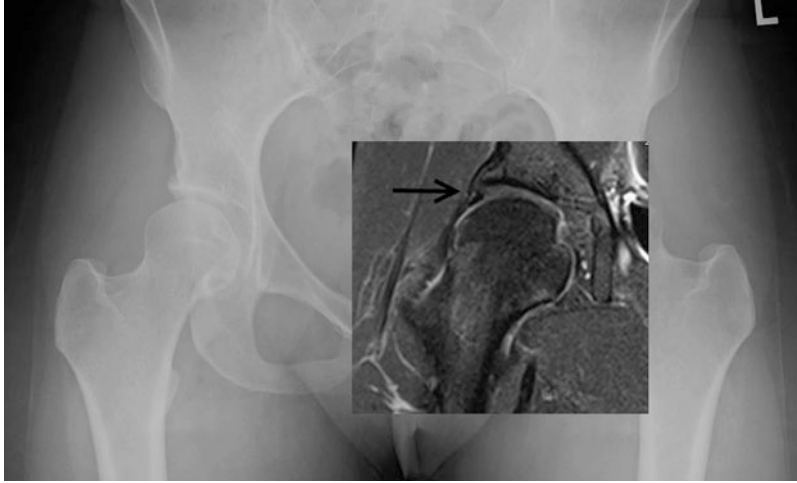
Patient with acetabular dysplasia seen on radiograph. On MRI, the acetabular labrum and cartilage is enlarged
